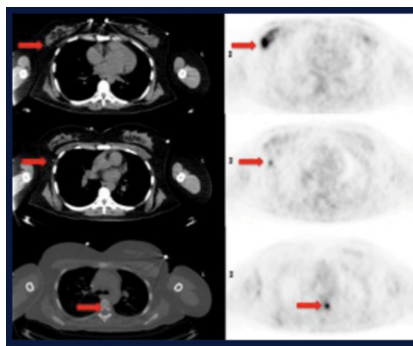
^{18}F FPPRGD₂ PET/CT in 44-year-old premenopausal woman with a newly diagnosed T₃N₂M₁ multicentric lobular carcinoma of the right breast shows the primary right breast lesion, right axillary lymph node, and thoracic spine metastases (all biopsy-proven). ^{18}F FDG PET/CT (not shown) did not identify these lesions.
